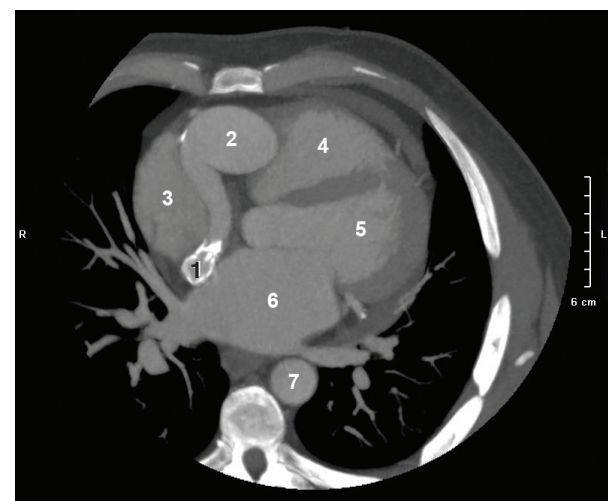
CT angiogram axial image at the level of the left atrium. 1, distal end of the tunnel; 2, proximal end of the tunnel; 3, right atrium; 4, right ventricle; 5, left ventricle; 6, left atrium. The tunnel is tortuous and dilated. Distally there are mural calcifications in the tunnel.
